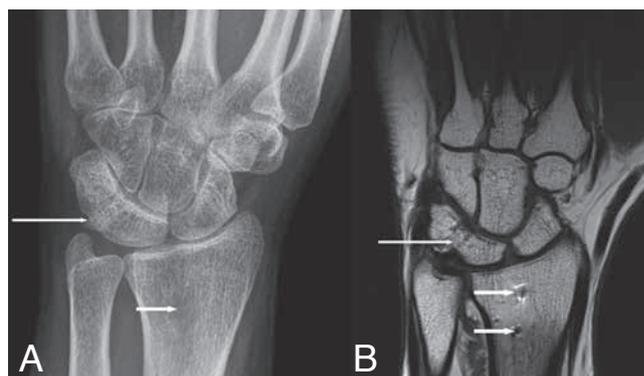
Secondary fusion due to surgery for a lunotriquetral ligament lesion. A: Plain radiography and B: Coronal SE T1-WI. There is a carpal “coalition” between the lunate bone and the triquetrum bone (long arrows). Notice the bony defect after pre-levation of a bone graft in the distal radius (A, short arrow) and the susceptibility artifacts after surgery (B, short arrows).
